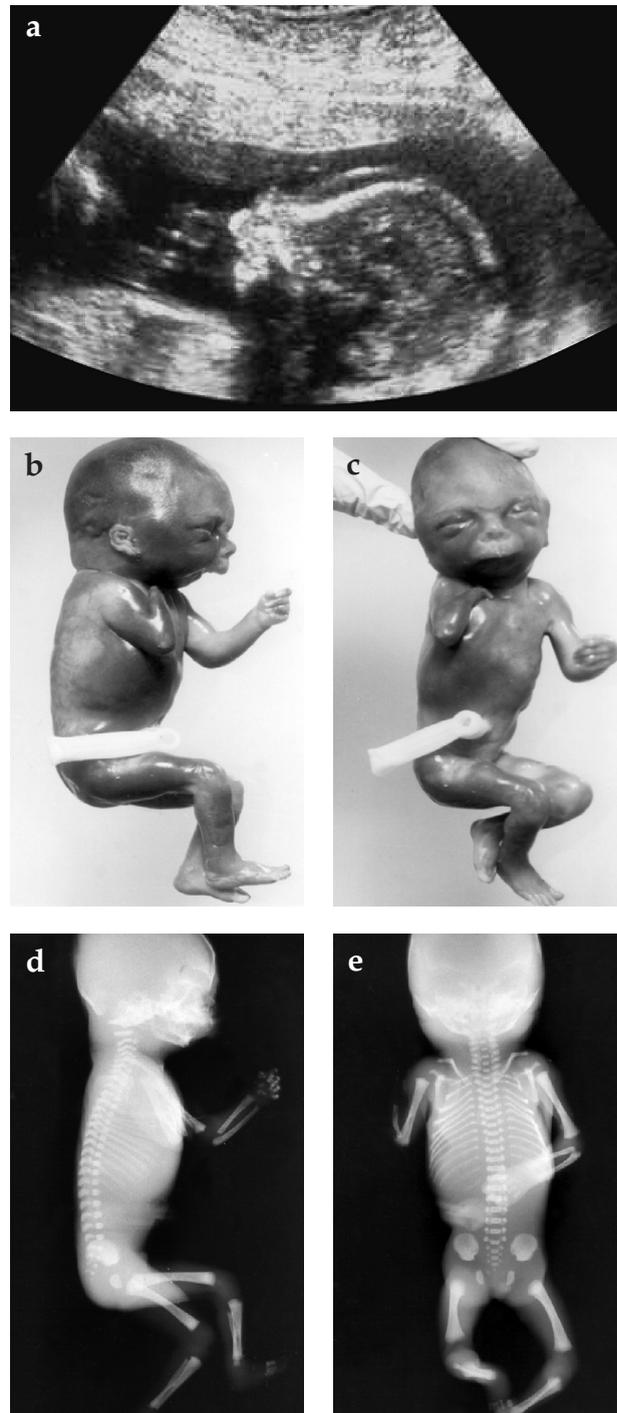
Ultrasound examination (a), total body view (b, c) and baby X-ray (d, e) of the propositus. (a) Ultrasound examination showing protruding upper lip with a long philtrum (nasolabial distance) and severe micro-/retrognathia. (b, c) Total body view showing the characteristic somatic changes, including anteverted nostrils, protruding upper lip with a long philtrum, downturned corners of the mouth, dysplastic ears, micro- and retrognathia as well as limb reduction defect on the right side. (d, e) Baby roentgenogram showing upper limb deficiency with agenesis of the right ulna bone and right monodactyly
